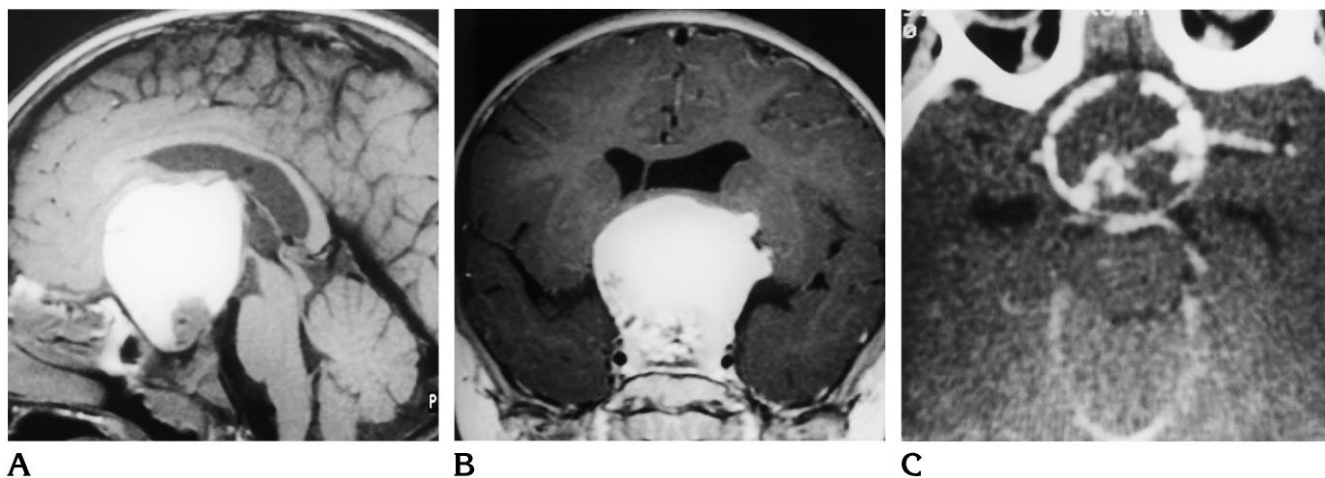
A, Noncontrast sagittal T1-weighted MR image shows a large intrasellar/suprasellar tumor with extension up to the foramen of Monro and associated hydrocephalus. A large hyperintense cyst and a small hypointense solid tumor are seen.
